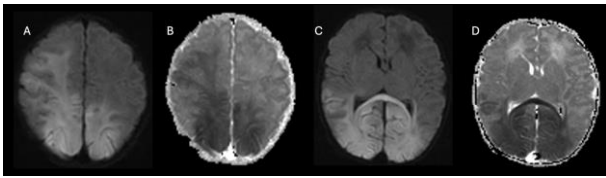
Hypoglycemic encephalopathy with characteristic posterior predominance. (A, B, C, D) Axial DWI and corresponding ADC maps demonstrate extensive cytotoxic edema with marked restricted diffusion predominantly affecting the parieto-occipital and temporal cortices bilaterally, with lesser involvement of the right frontal lobe. This posterior distribution pattern with relative sparing of the thalami, cerebellum, and brainstem is characteristic of hypoglycemic brain injury.
